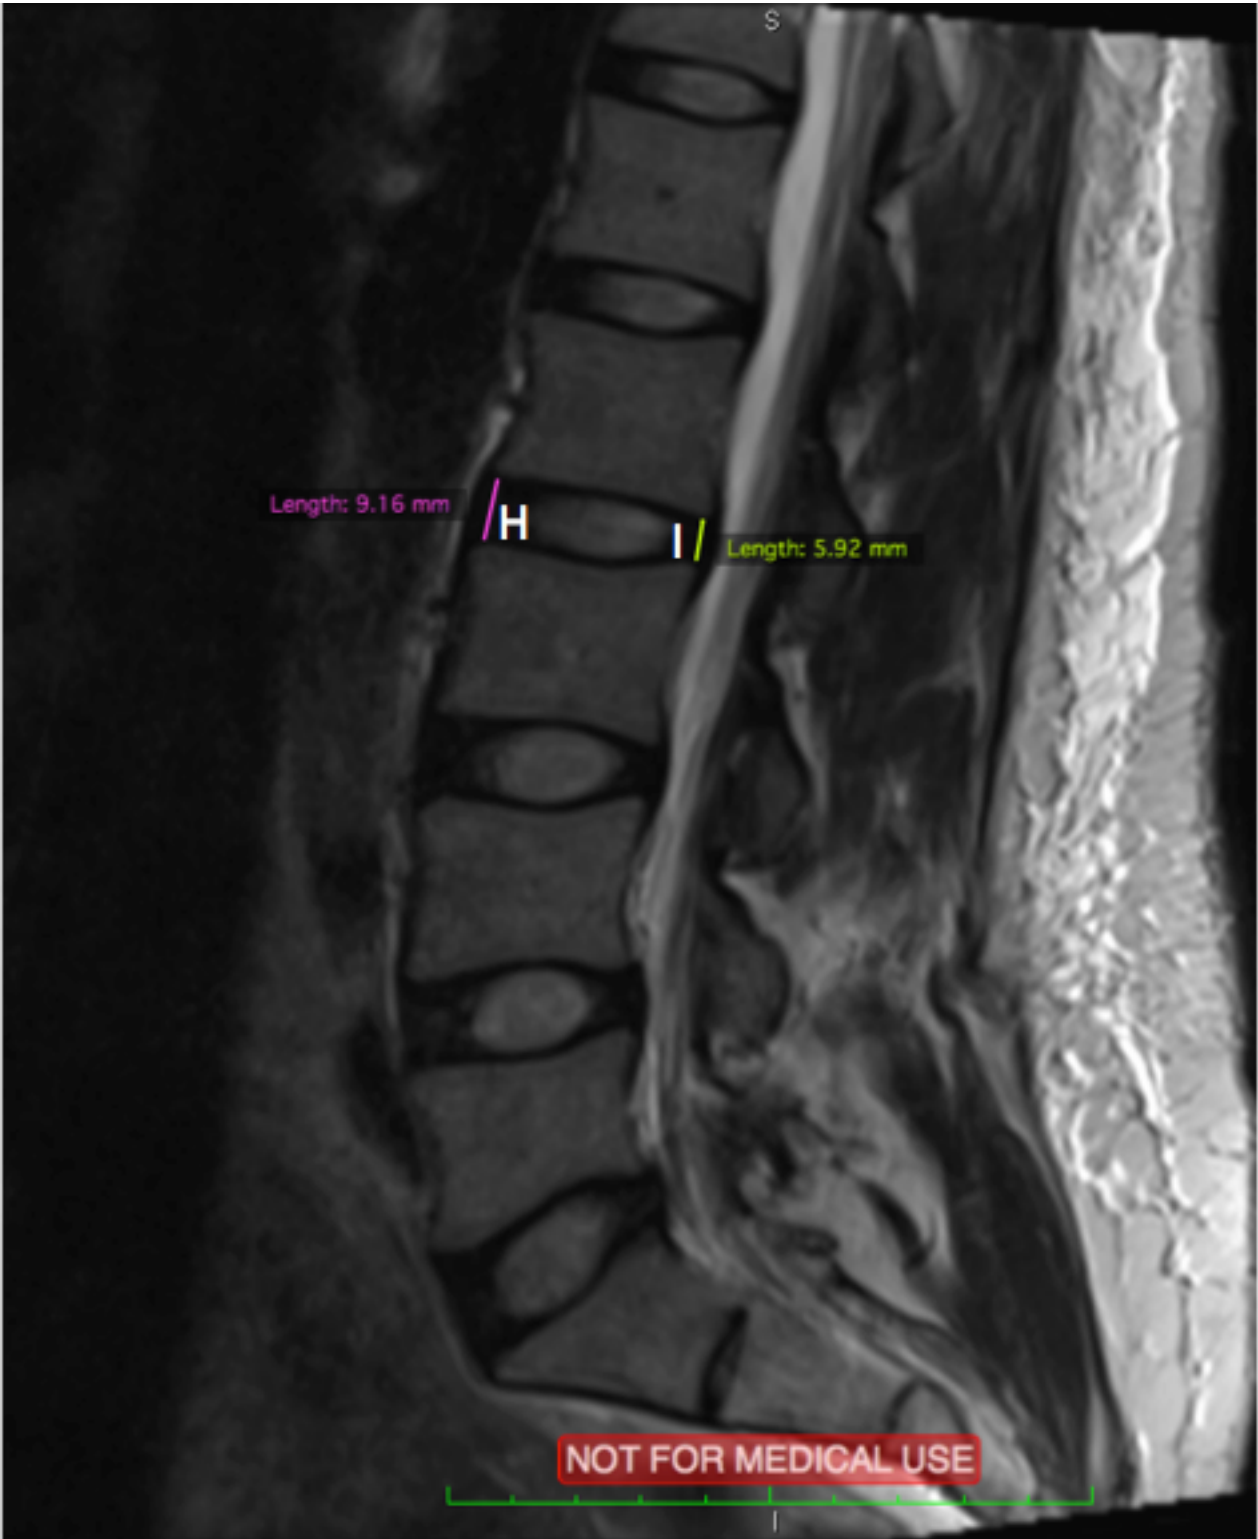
Sagittal MRI scan with measurements of H (Anterior IVD Height), and I (Posterior IVD Height)
